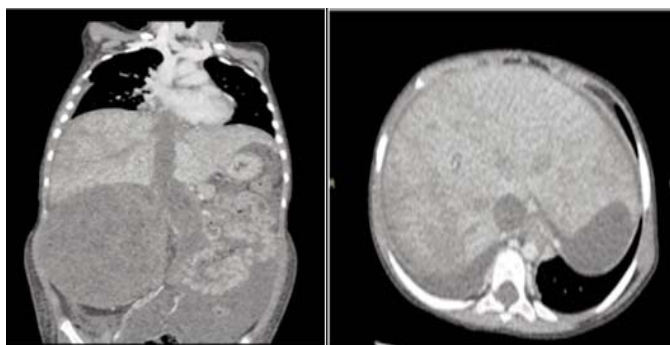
Contrast enhanced CT Chest, abdomen, and pelvis. Coronal and axial images showing large right hemi abdominal Wilms tumour with tumour thrombus involving IVC, extending superiorly to right atrium.
